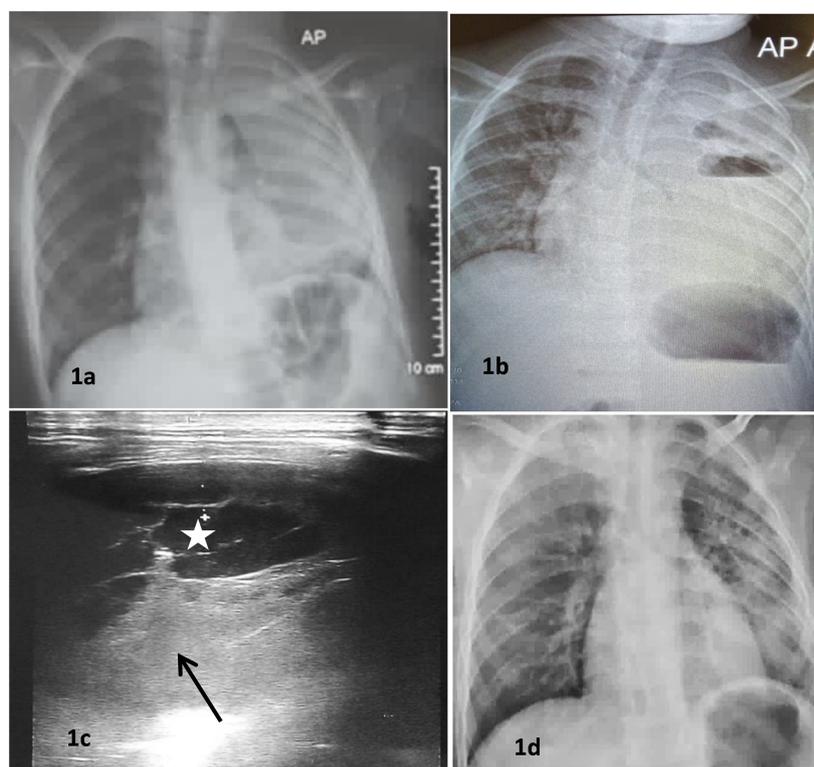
The three X-rays performed and the pleuropulmonary ultrasound. The initial image (1a) revealed an almost complete left lung white-out. After 2 weeks of broad-spectrum antibiotic therapy with no favourable follow-up, the control image (1b) showed the appearance of an air-fluid level within the left lung white-out. The post-therapeutic evaluation X-ray at one month showed a resumption of pulmonary aeration (1d). On pleuropulmonary ultrasound (1c), there was a parapneumonic pleural effusion (white star) associated with contiguous pulmonary consolidation (black arrow).
